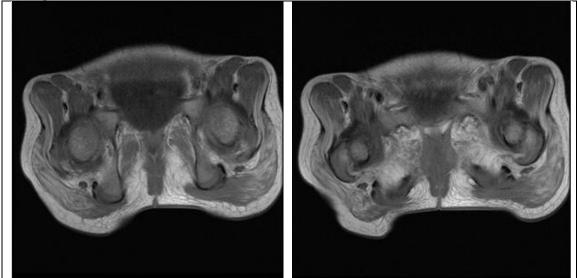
Dixon MRI showing patchy fat infiltration with sparing of vastus medialis. And bilateral adductor minimus muscles
